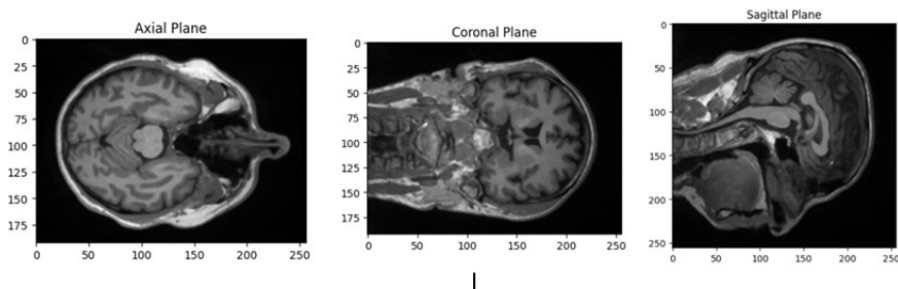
MRI with 3D Dimension
